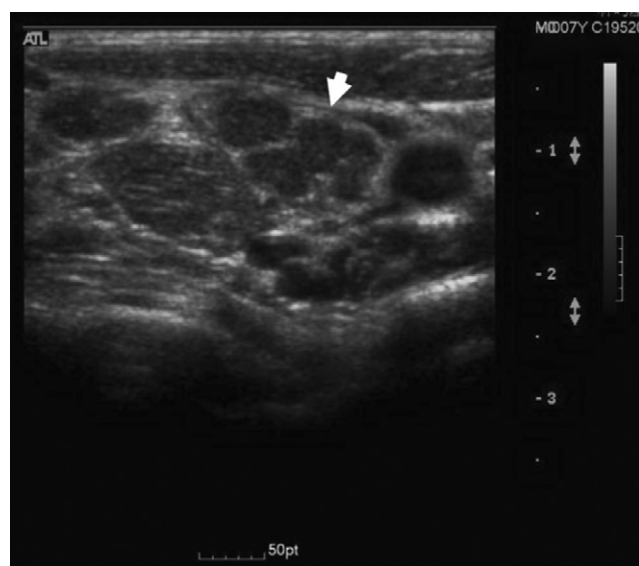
Axial ultrasound scan at left posterior triangle demonstrated multiple, hypoechoic, enlarged confluent lymph nodes with hyperechoic rims (arrow).
